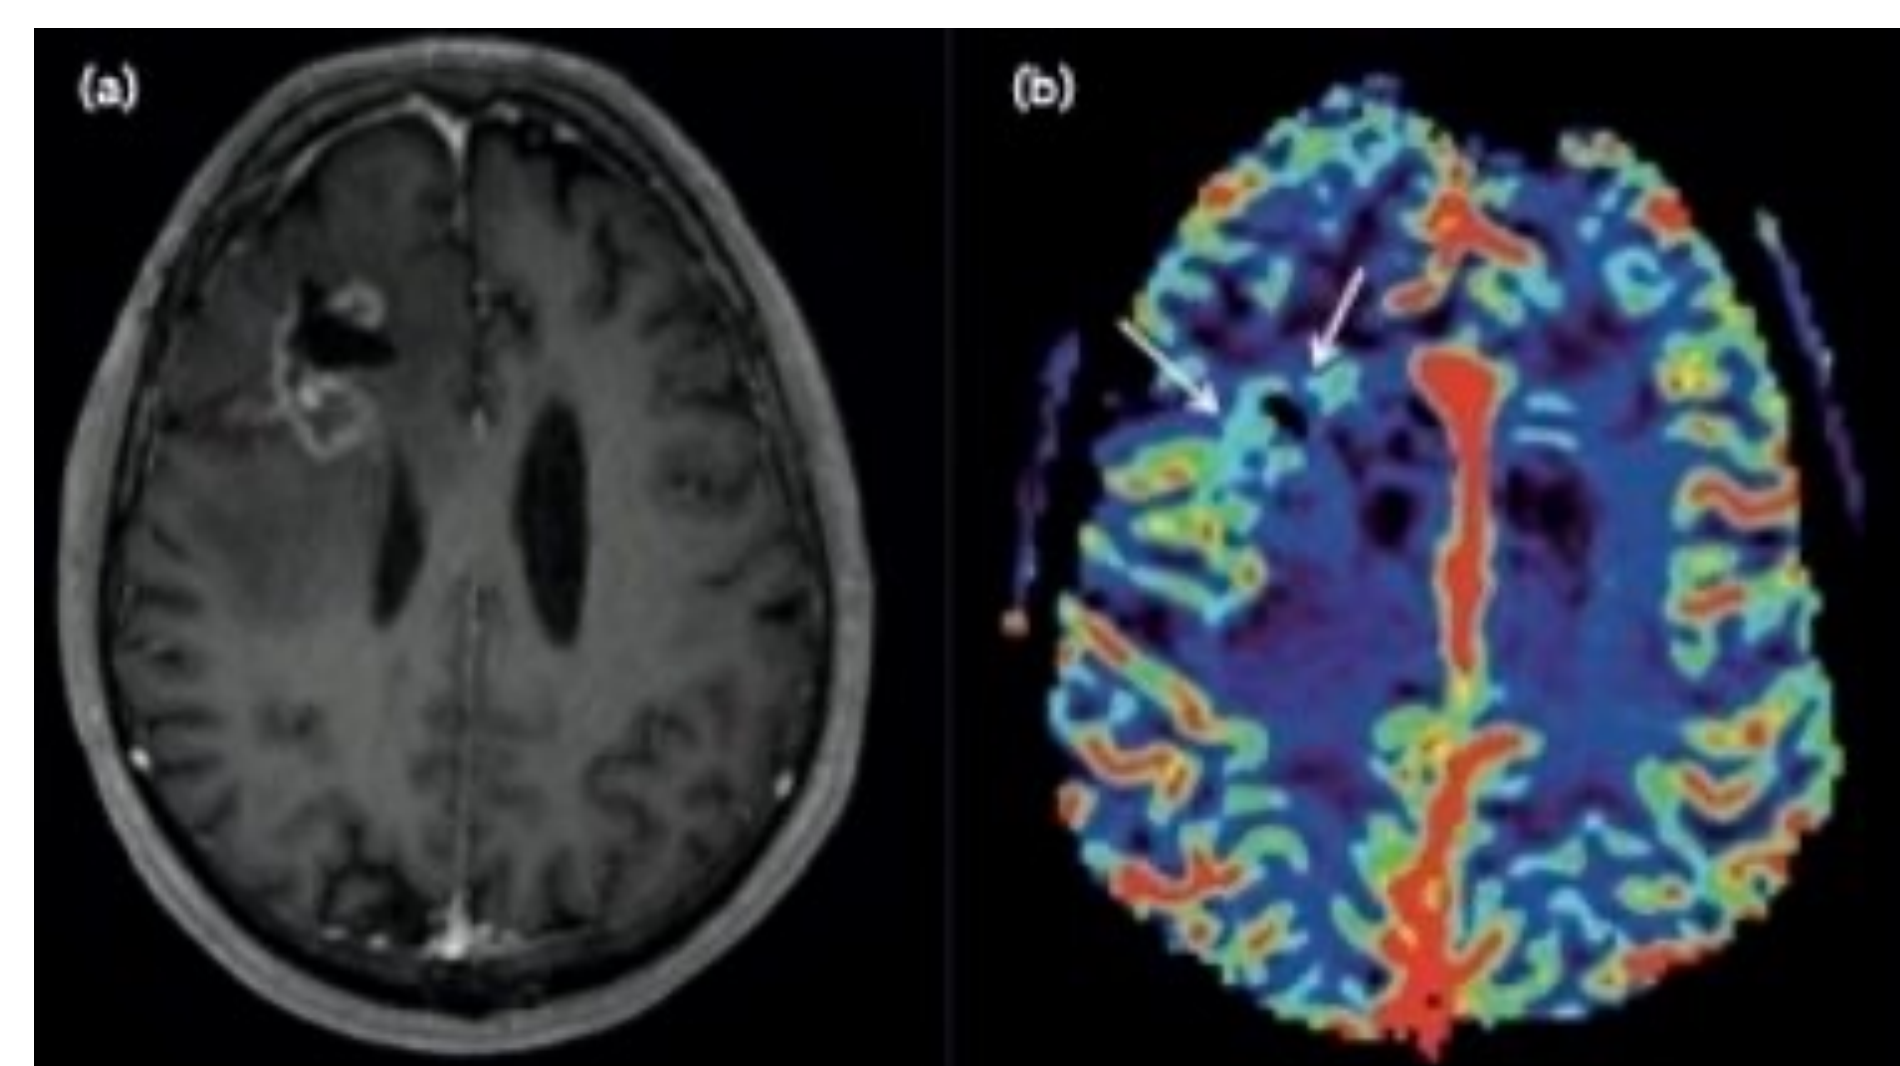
Perfusion MRI to see neovascular tumor (McNamara et al., 2020, p. 31)
